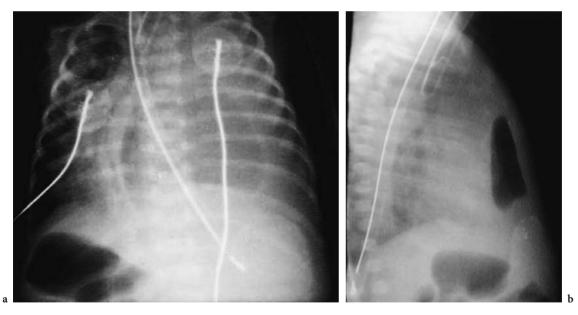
Esophageal perforation after orogastric tube malposition. a Frontal chest radiograph with left pleural effusion, left pulmonary atelectasis and mediastinal shift. Free air overlies the cardiac silhouette. b Lateral chest radiograph confirms the traumatic pneumothorax
